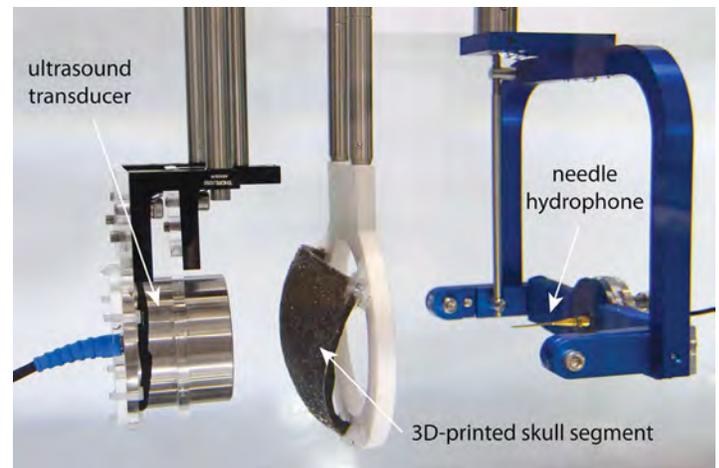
Measurement of the acoustic field behind a 3-D-printed skull segment (center) using a focused ultrasound transducer (left) and a needle hydrophone (right) in a water tank.
